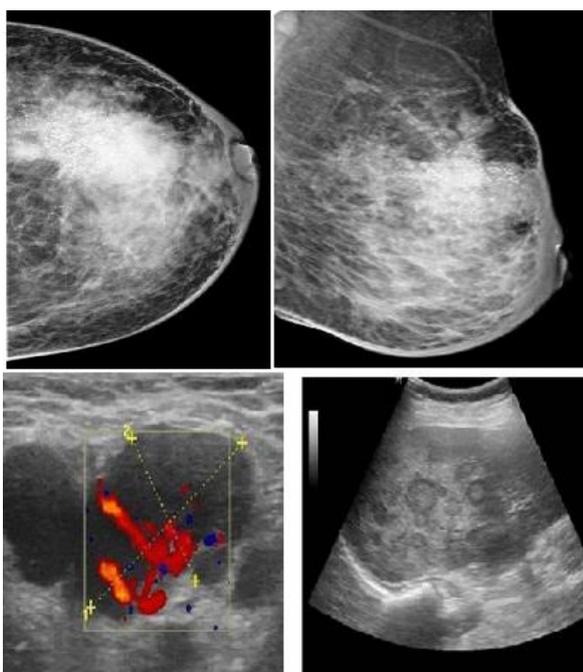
Invasive Ductal Carcinoma: Mammography image (Left breast - cranio-caudal and oblique) and sonography image shows axillary lymph node and liver metastasis
